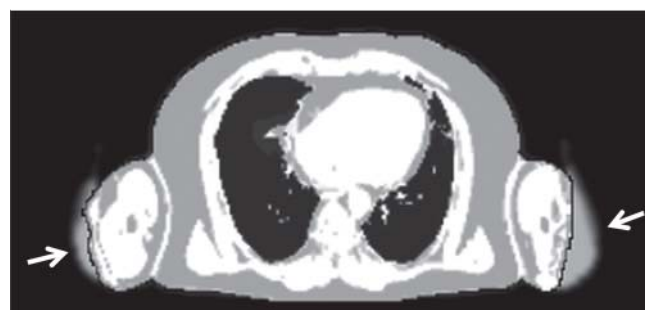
An attenuation map based on segmentation of 2-point Dixon MR images in axial layer orientation through the thorax (Siemens Biograph mMR, syngo MR B20P). Due to the limited MRI field of view in the case of large patients, frequently appearing truncation artifacts in the region of the arms were partially corrected from PET emission data (arrows) using maximum likelihood reconstruction of attenuation and activity (MLAA). One should also note that the attenuation map does not differentiate between soft tissue (e. g. muscle) and bone which results in underestimation of PET signals during quantitative assessment.
